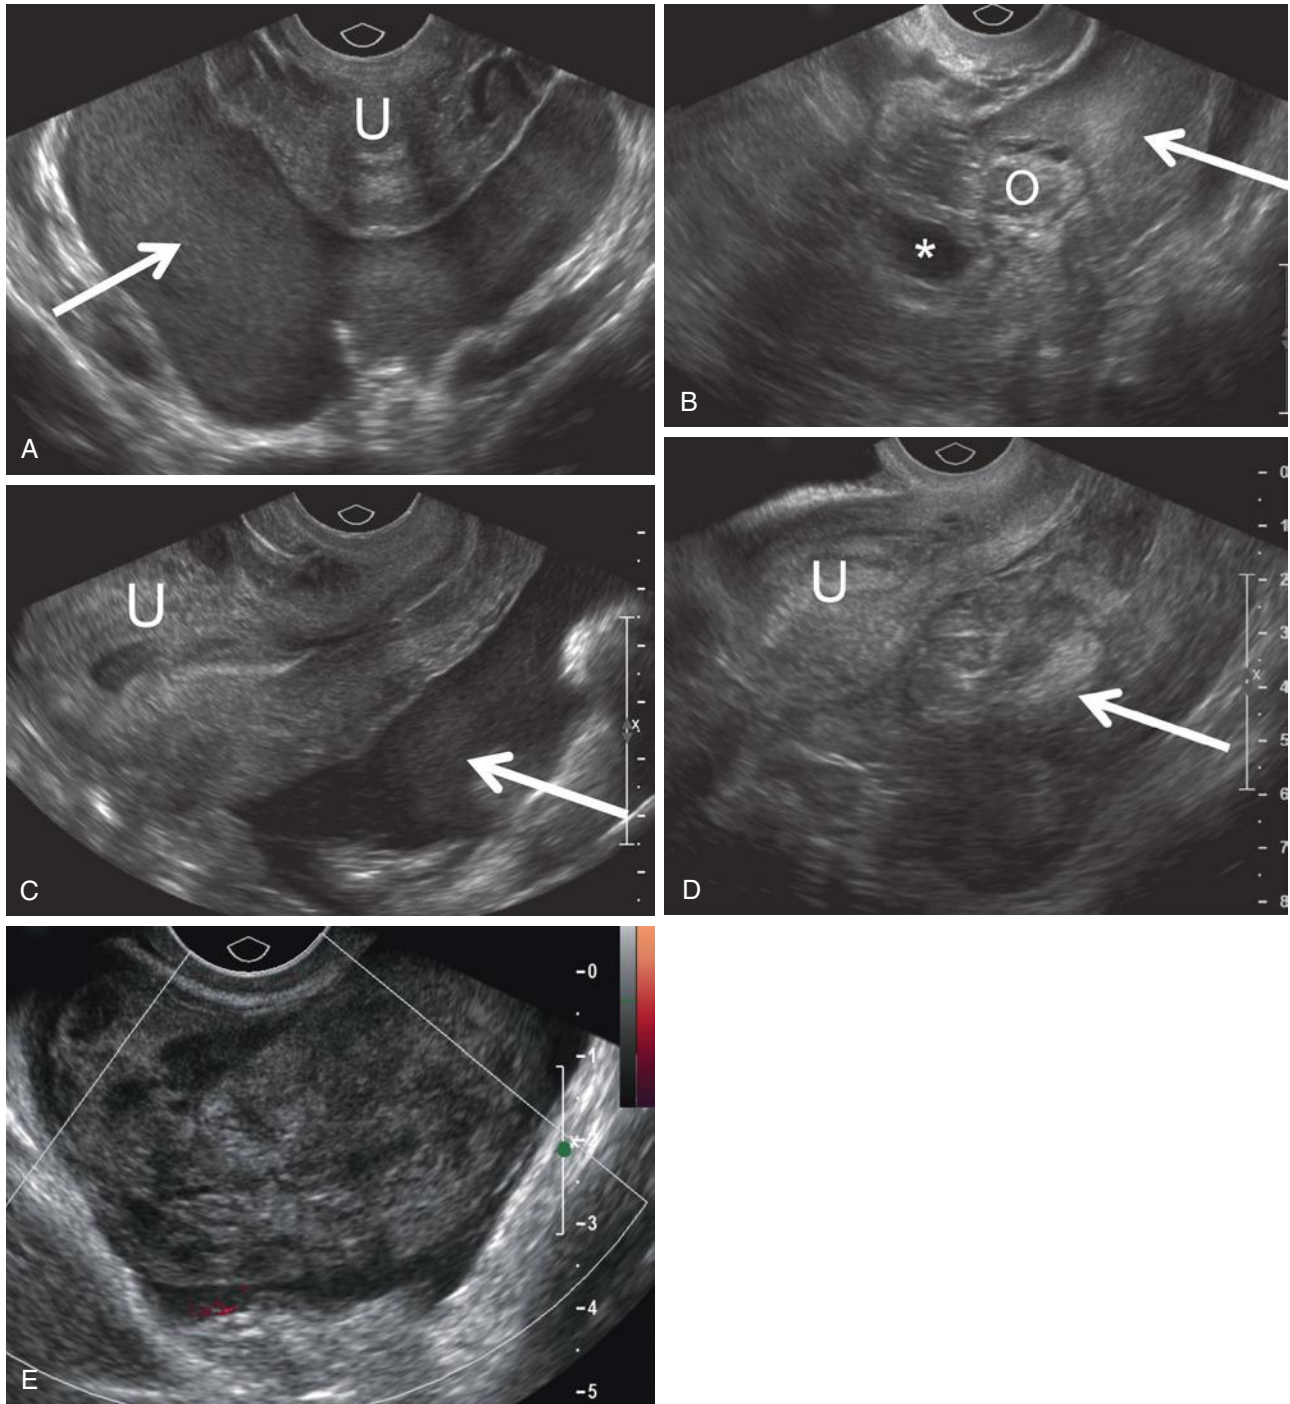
Variable sonographic appearance of hemoperitoneum due to rupture of ectopic pregnancy. A, Transvaginal transverse scan shows homogeneous, low-level echoes representing blood (*arrow*) in the cul-de-sac, posterior to the uterus (U). B, Echogenic hemoperitoneum (*arrow*) outlines the ovary (O), which contains several small anechoic follicles, and an ectopic gestational sac (*asterisk*) with an echogenic rim. C, Hemoperitoneum, shown posterior to the uterus (U), is nearly anechoic in this patient with a small area of low-level echoes (*arrow*). Note a small amount of fluid in the endometrial cavity. D, Transvaginal longitudinal pelvic scan shows complex heterogeneous clotted blood (*arrow*) posterior to the uterus (U) mimicking bowel loops. E, Transvaginal transverse power Doppler scan through the cul-de-sac shows complex heterogeneous material with no demonstrable internal blood flow, consistent with clotted blood. Note that there is a small amount of adjacent anechoic free fluid.
